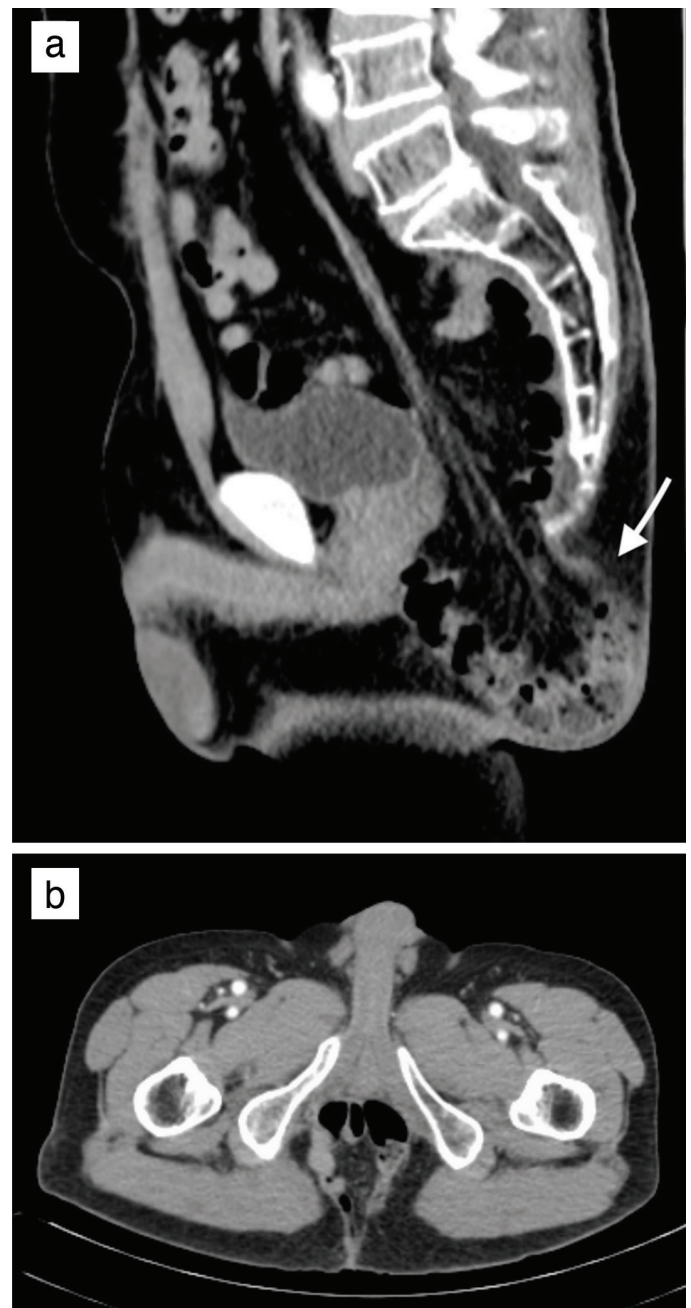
Contrast-enhanced computed tomography of the pelvis demonstrating herniating small bowel and mesentery through perineal floor defect: a) sagittal view and b) axial view
